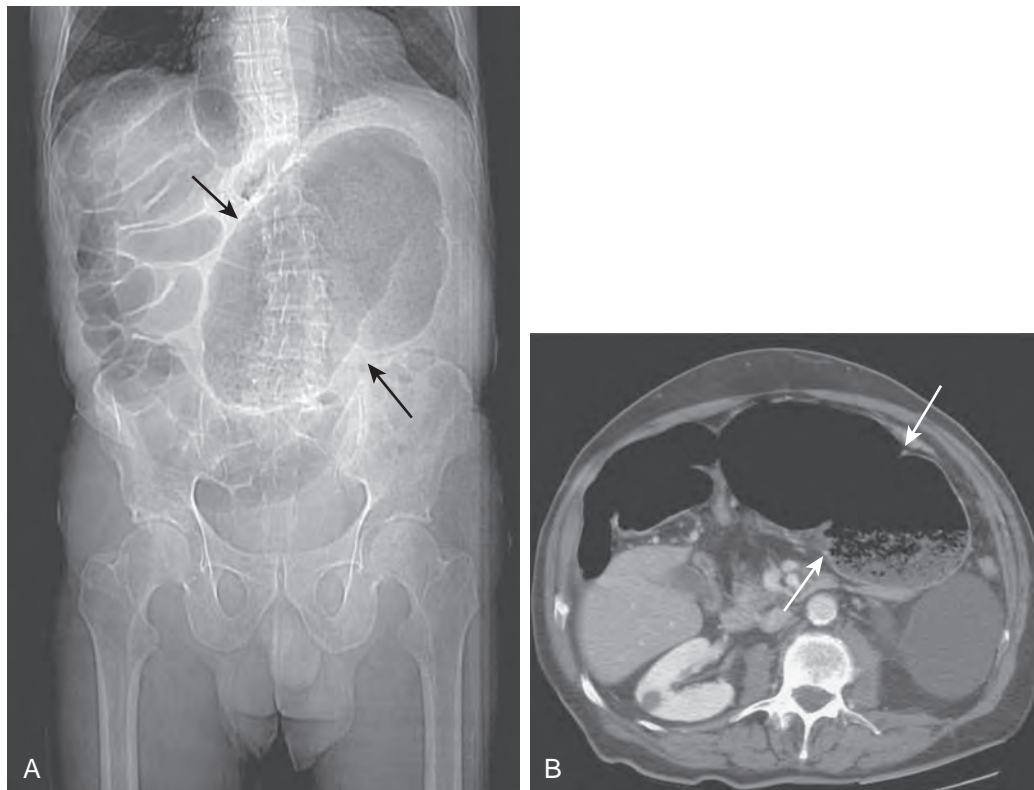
Cecal volvulus: CT features. A. Scout image shows that a distended cecum (arrows) is present in the left upper quadrant, with multiple dilated small bowel loops in the right upper quadrant. B. CT scan demonstrates the malpositioned cecum (arrows) and swirling of the mesentery.
